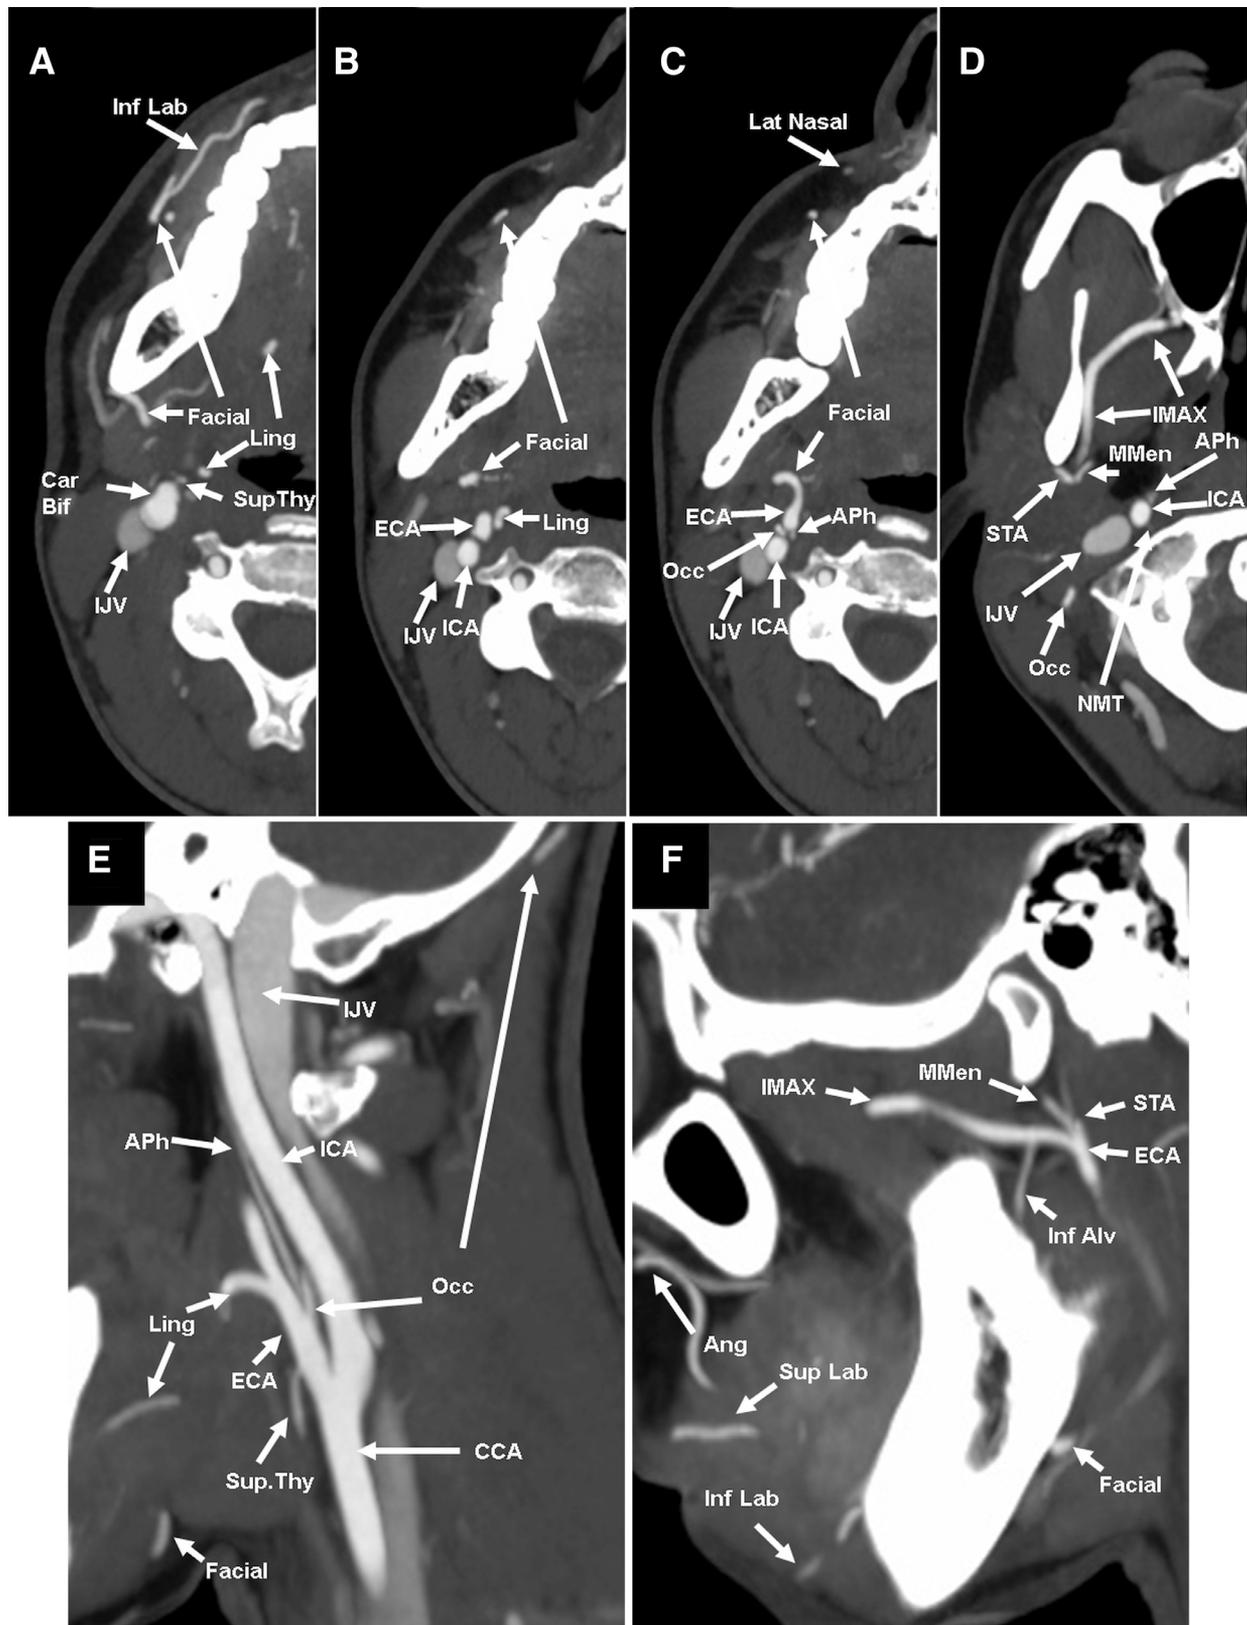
Axial (A-D) and sagittal (E-F) maximum intensity projection images (MIPs) from CT angiogram through the lower face and jaw. Ang, angular artery; APh, ascending pharyngeal artery; Car Bif, carotid bifurcation; CC, common carotid artery; ECA, external carotid artery; ICA, internal carotid artery; IJV, internal jugular vein; Inf Lab, inferior labial artery; IMAX, inferior maxillary artery; Lat Nasal, lateral nasal artery; Ling, lingual artery; MMen, middle meningeal artery; NMT, neuromeningeal trunk; Occ, occipital artery; STA, superficial temporal artery; Sup Thy, superior thyroidal artery.
